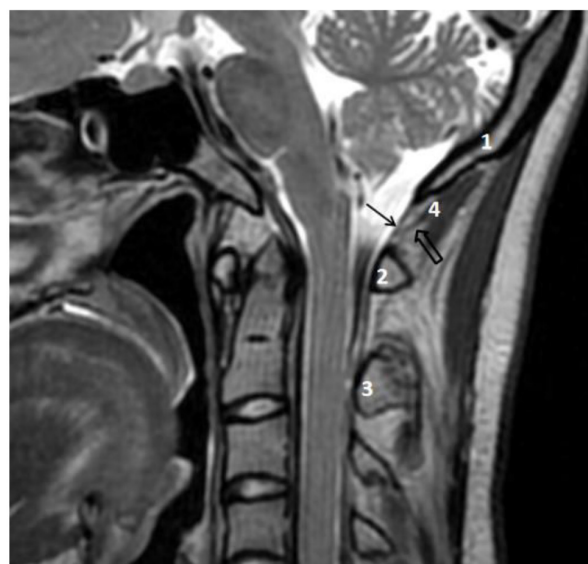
Oblique sagittal T₂-weighted MR image demonstrates hypo-intense myodural bridge (blank arrow) between the rectus capitis posterior minor muscle and cervical spinal dura mater (black thick arrow) at the posterior atlanto-occipital interval. (1. occipital bone, 2. atlas, 3. axis, 4. rectus capitis posterior minor muscle).
